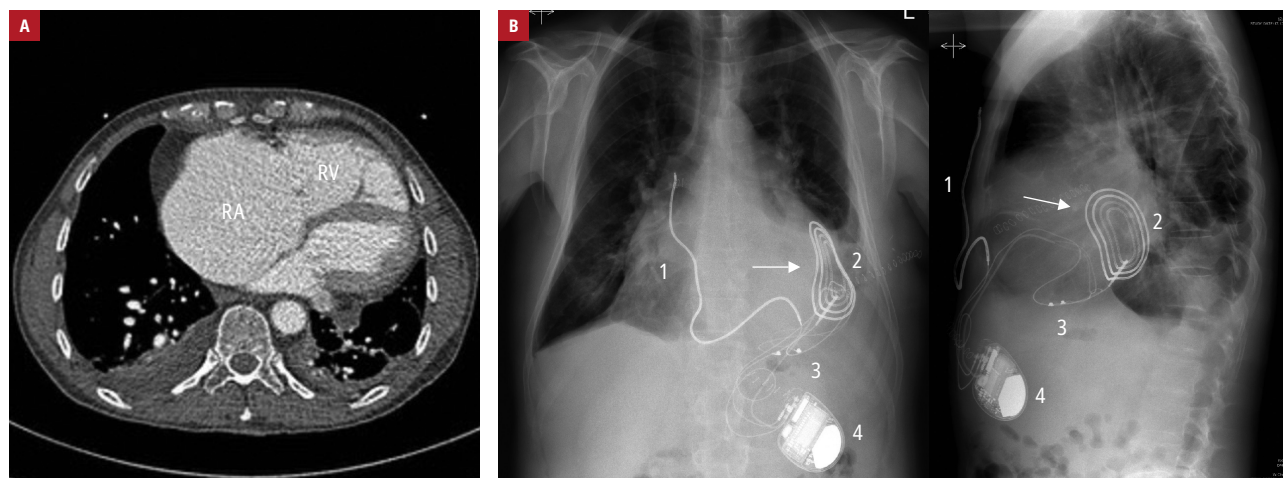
Chest computed tomography (CT) before and chest radiography after hybrid implantable cardioverter-defibrillator (ICD) implantation in a patient with Eisenmenger syndrome: A – a CT scan demonstrating features of advanced pulmonary hypertension with severely enlarged right atrium (RA) as well as enlarged and hypertrophied right ventricle (RV); B – posteroanterior and lateral chest radiographs showing the hybrid ICD device components: 1) subcutaneous defibrillator lead positioned along the right parasternal border; 2) epicardial defibrillator patch on the posterior left ventricular wall; 3) epicardial pacing lead in the RV apical region; and 4) ICD generator in the upper-left abdominal region. Arrows indicate the defibrillation vector programmed between the subcutaneous defibrillator lead and epicardial defibrillator patch.
